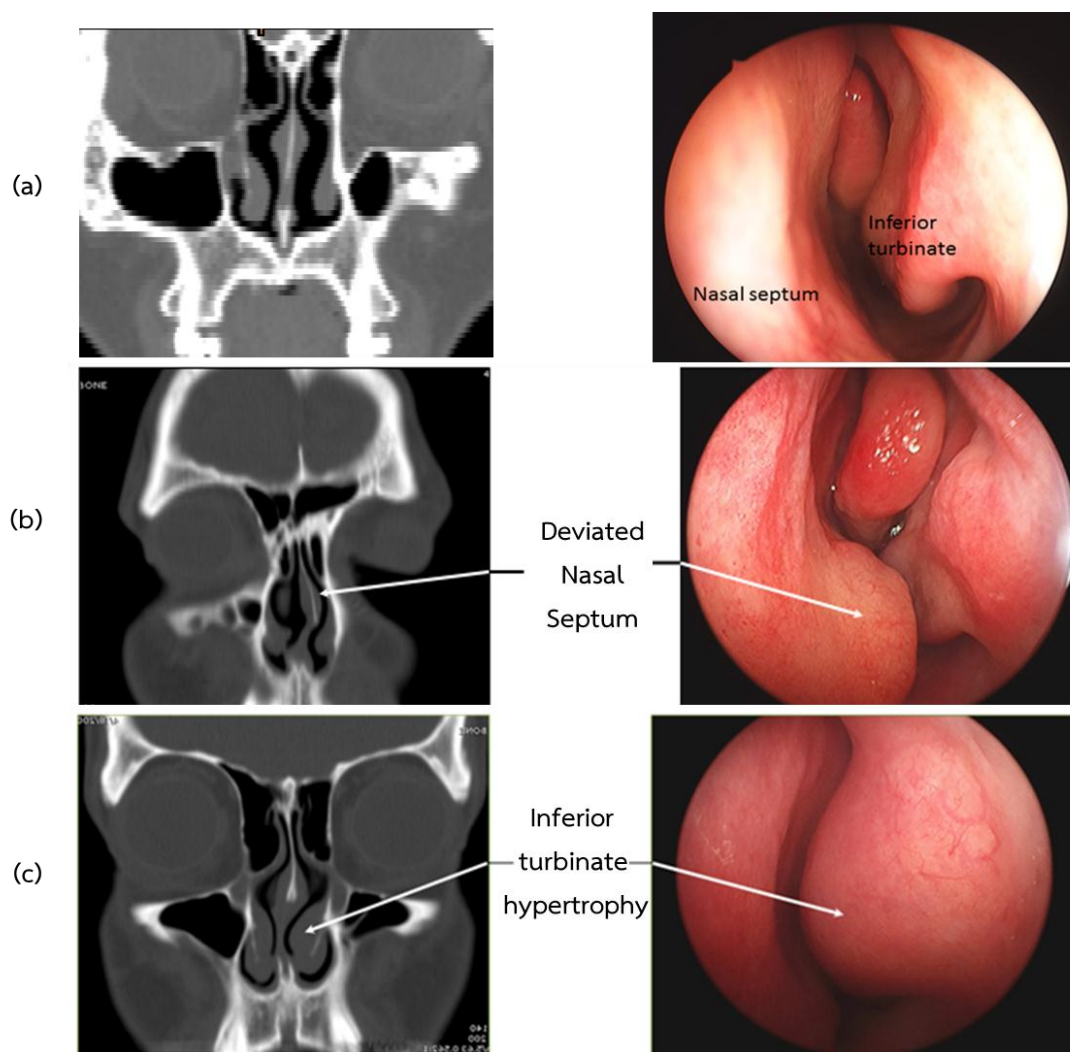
Comparison of CT and endoscopic images at the corresponding positions. (a) Normal nasal septum. (b) presents leftward DNS. (c) presents rightward DNS with inferior turbinate hypertrophy. [55] (figure was modified from [http://care.american-rhinologic.org/septoplasty\\_turbinates](http://care.american-rhinologic.org/septoplasty_turbinates))
